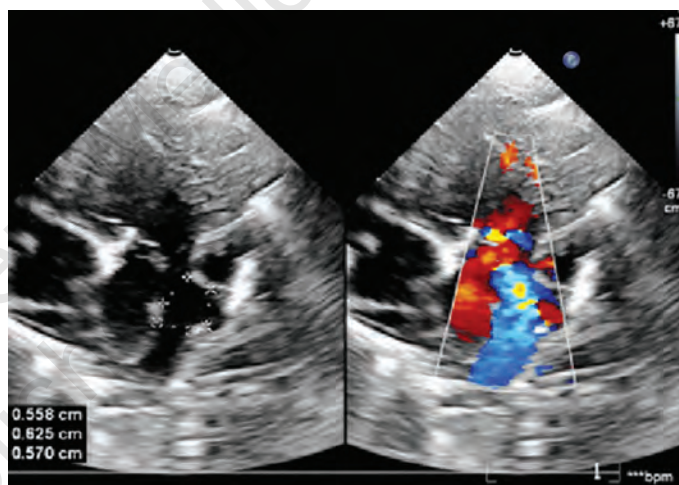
Truncus arteriosus: Apical four-chamber view, type I truncus.
